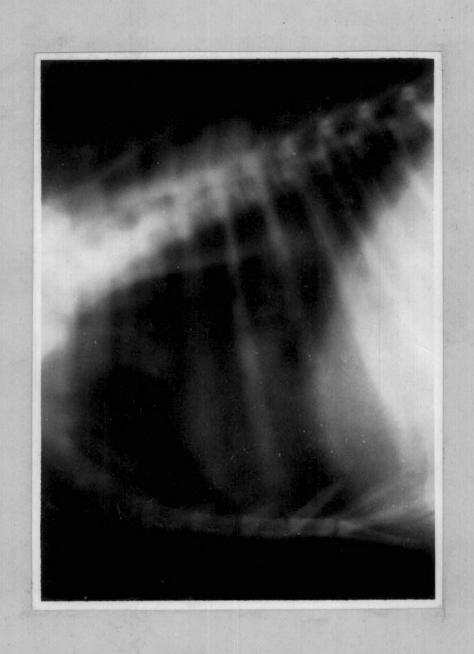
Radiograph of thomax after thomscotomy and labectomy by rib resection technique. Cut end of the rib is marked.
